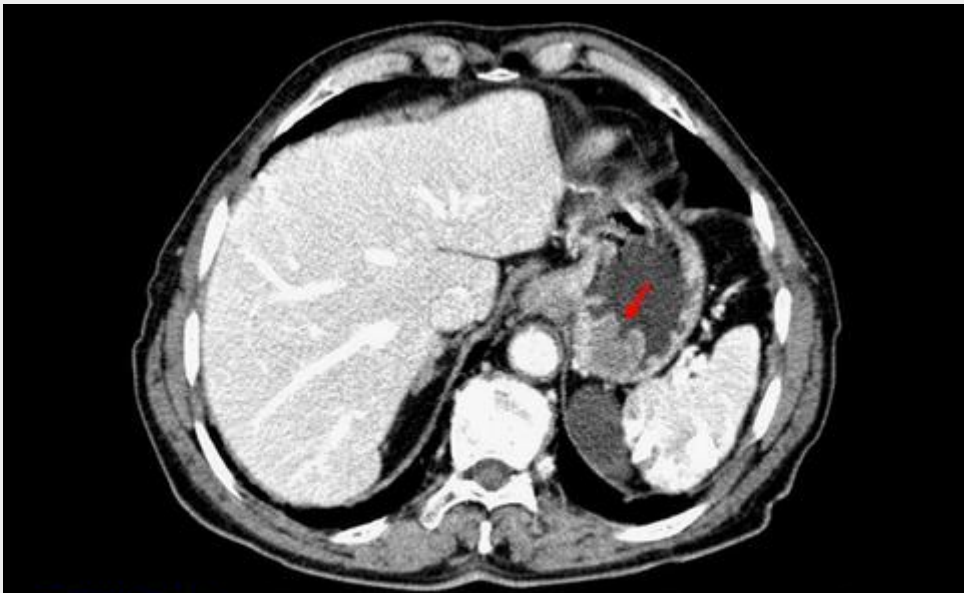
GIST. Post-contrast CT study. The mass enhances moderately and homogeneously. Note hyperenhancing mucosa covering the lesion, in accordance with its submucosal origin, except at its endoluminal pole, where an ulceration is found (→).
